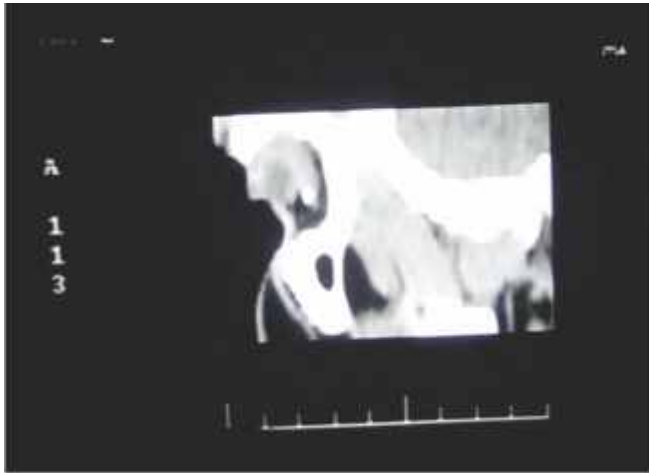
CT scan showing orbital fracture
